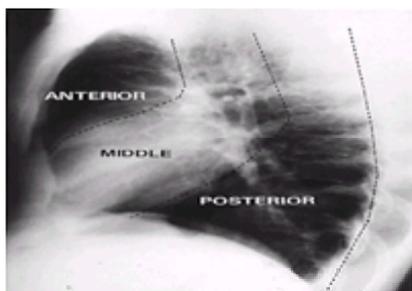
Lateral chest x-ray film demonstrating the three compartments of the mediastinum. (Reproduced from Sabiston DC Jr, Oldham HN Jr, The mediastinum. In: Sabiston DC Jr, Spencer FC, eds. *Gibbon's Surgery of the Chest*, 4th ed. Philadelphia: WB Saunders, 1983.)
